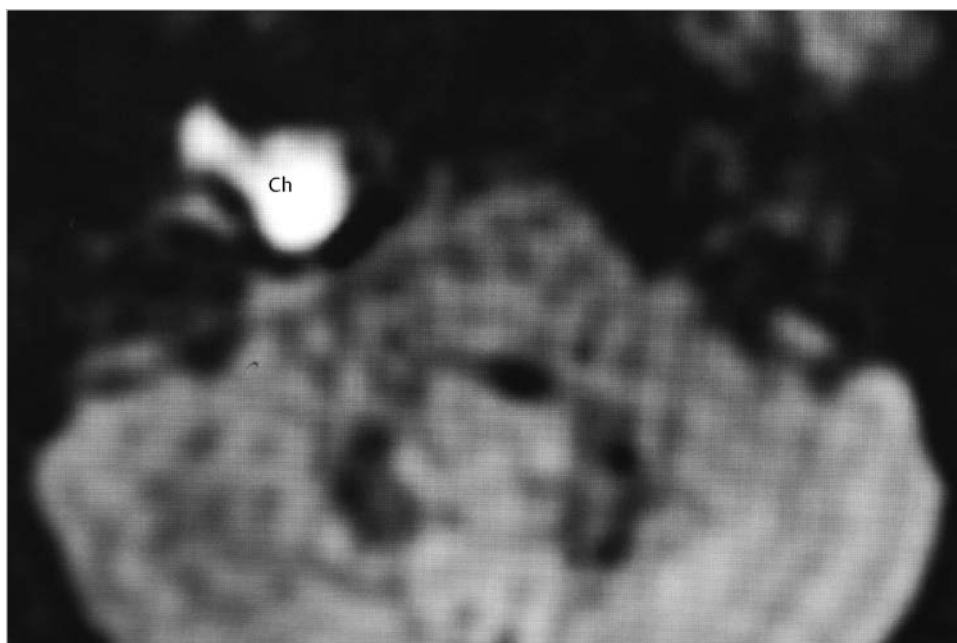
The diffusion-weighted MR imaging sequence clearly discriminates the cholesteatoma with its high signal from surrounding structures. Ch, cholesteatoma.
